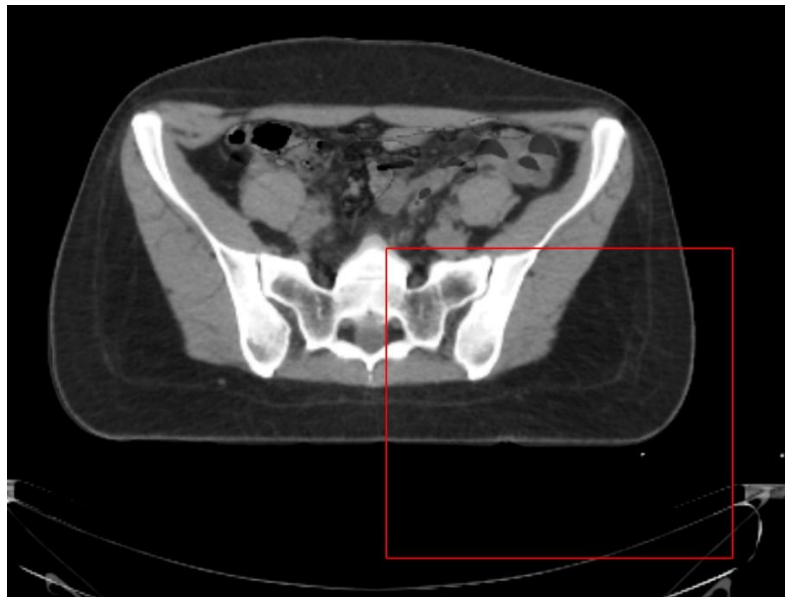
Axial CT image with the selected ROI used for the laterality test.
